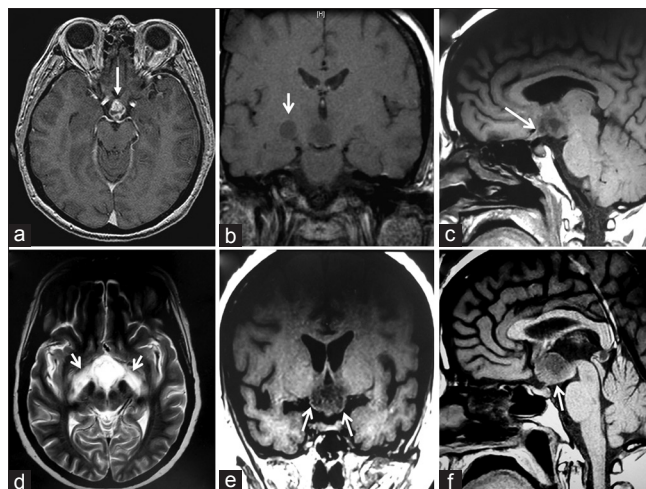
Preoperative magnetic resonance imaging (MRI) studies. (a, b) Initial MRI study, axial (a) and coronal (b) T1-weighted scans (1/25/2012), showing a heterogeneous solid-cystic lesion centered at the chiasmatic recess of the third ventricle. Note the anterior tongue-like tumor protrusion into the optic chiasm (white arrow). In the coronal image, there is a round hypointense area of similar low intensity as the tumor is visible over the trajectory of the right optic tract (white arrow). (c-f) Preoperative MRI study obtained 6 months later, just prior to the surgical procedure (7/13/2012), showing enlargement of the tumor. The finger-like tumor tissue projecting into the optic chiasm-right optic nerve can be identified (white arrow). (d) Axial T2-weighted preoperative MRI scan, showing hyperintense symmetrical signals following the course of both optic tracts, a sign known as "moustache sign," which is believed to correspond to optic tract edema (white arrows). (e, f) Coronal and midsagittal T1-weighted scans demonstrating the strictly third ventricle topography of this craniopharyngioma, which has developed above an intact third ventricle floor/pituitary stalk (white arrows)
